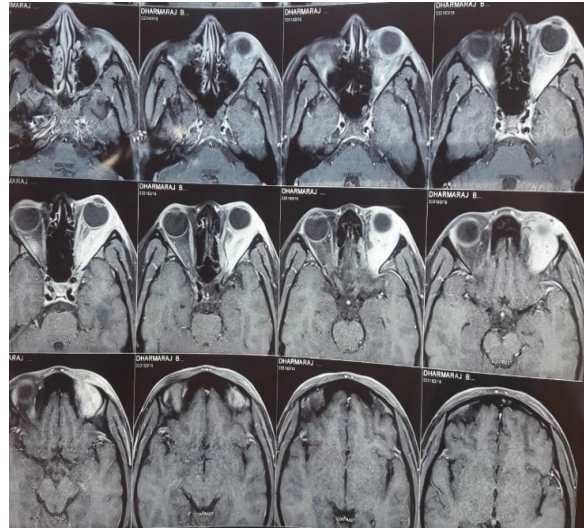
MRI showing orbital cellulitis
